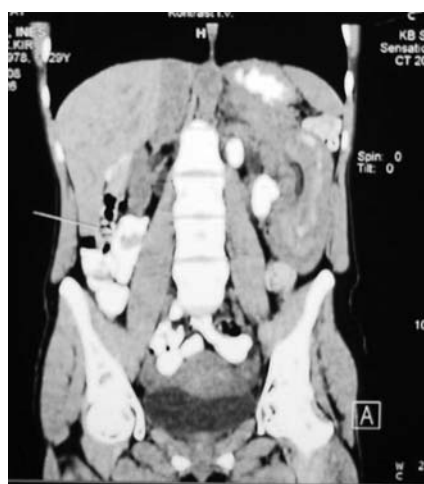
Multislice computed tomography of abdomen. Large polyp that caused intussusception and two more polypoid intraluminal structures; one beneath large polyp on left side, another at right upper abdomen in the level of caudal liver margin.
